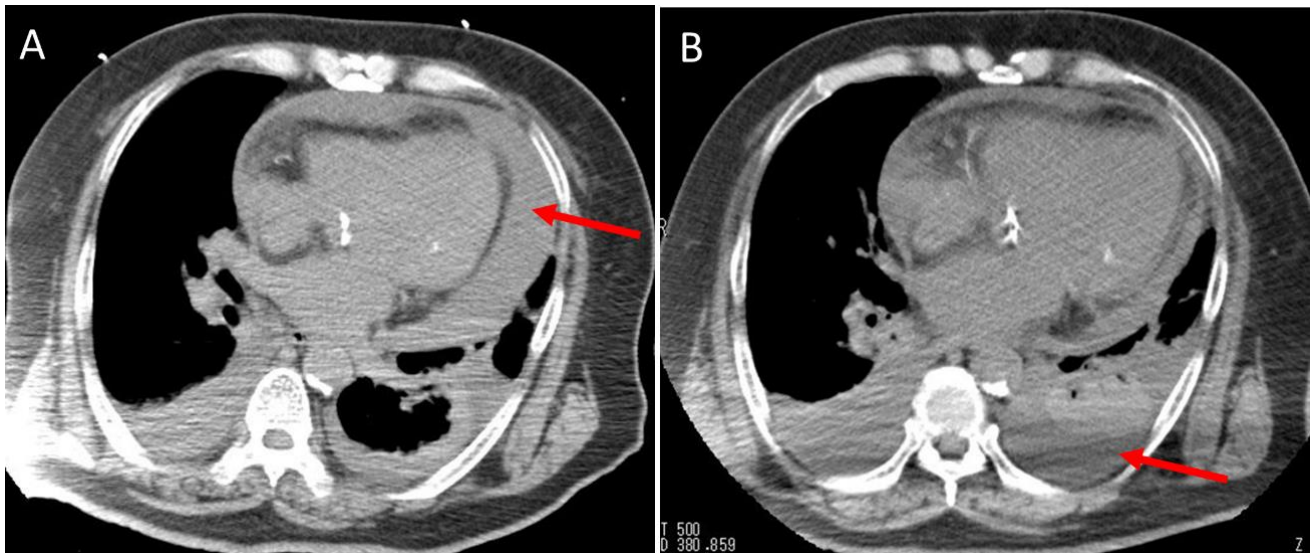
Computed tomography (CT) imaging before and after transthoracic echocardiography-guided pericardiocentesis. (A) Pre-procedural CT scan revealing the presence of extensive fluid collection (arrow), which was predominantly in the pericardial cavity. (B) Procedure-related epicardial injury causing a shift of fluid from the pericardial cavity to the thoracic cavity (arrow).
